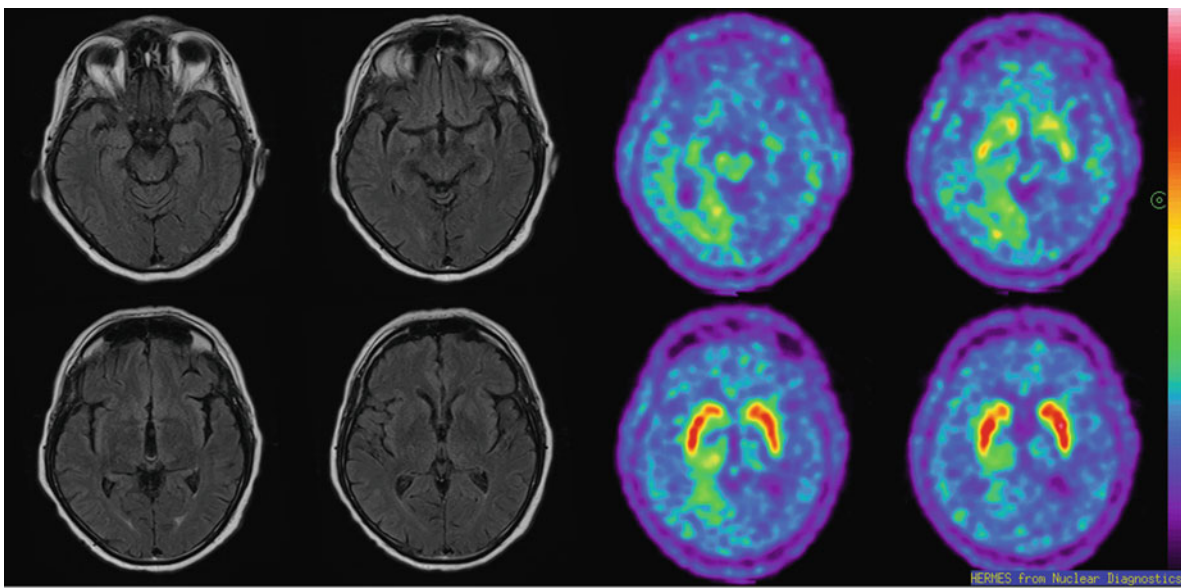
The 71 year old male patient suffered from acute stroke involving the right posterior cerebral artery. We present the MRI and DOPA PET images (subacute) from September
